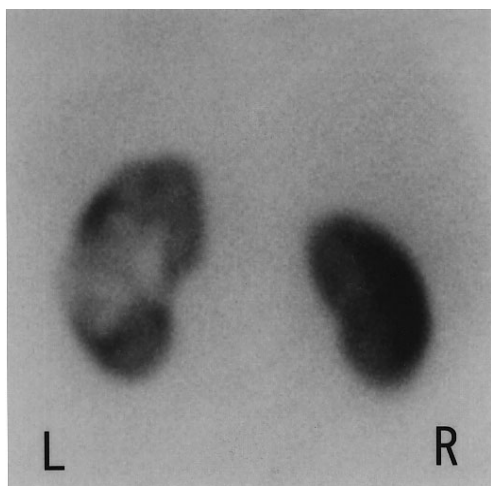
^{99m}Tc -dimercaptosuccinic acid scintigraphy from a posterior view. A space-occupying lesion in the left kidney was visualized as a cold area with ^{99m}Tc -dimercaptosuccinic acid.
